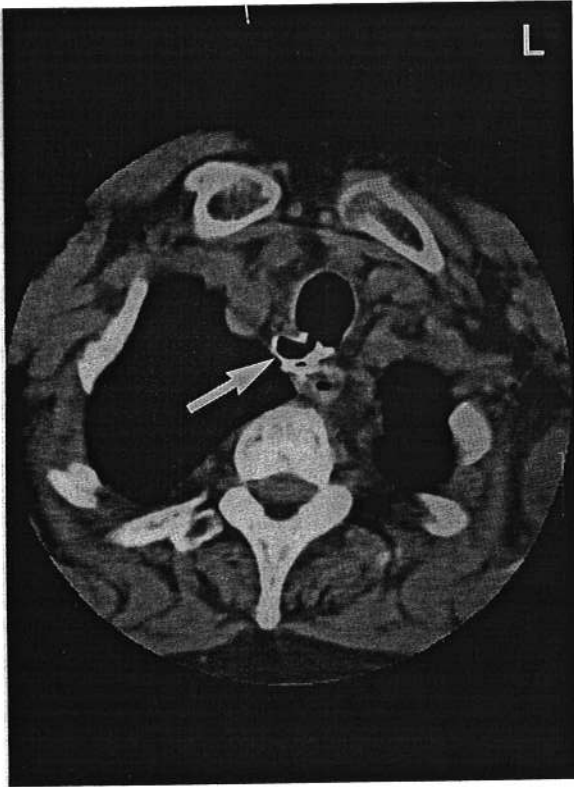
Computed tomographic (CT)-scan of the mediastinum, after contrast tracheobronchography, demonstrates a tracheocele from the posterior wall of the trachea (arrow).
